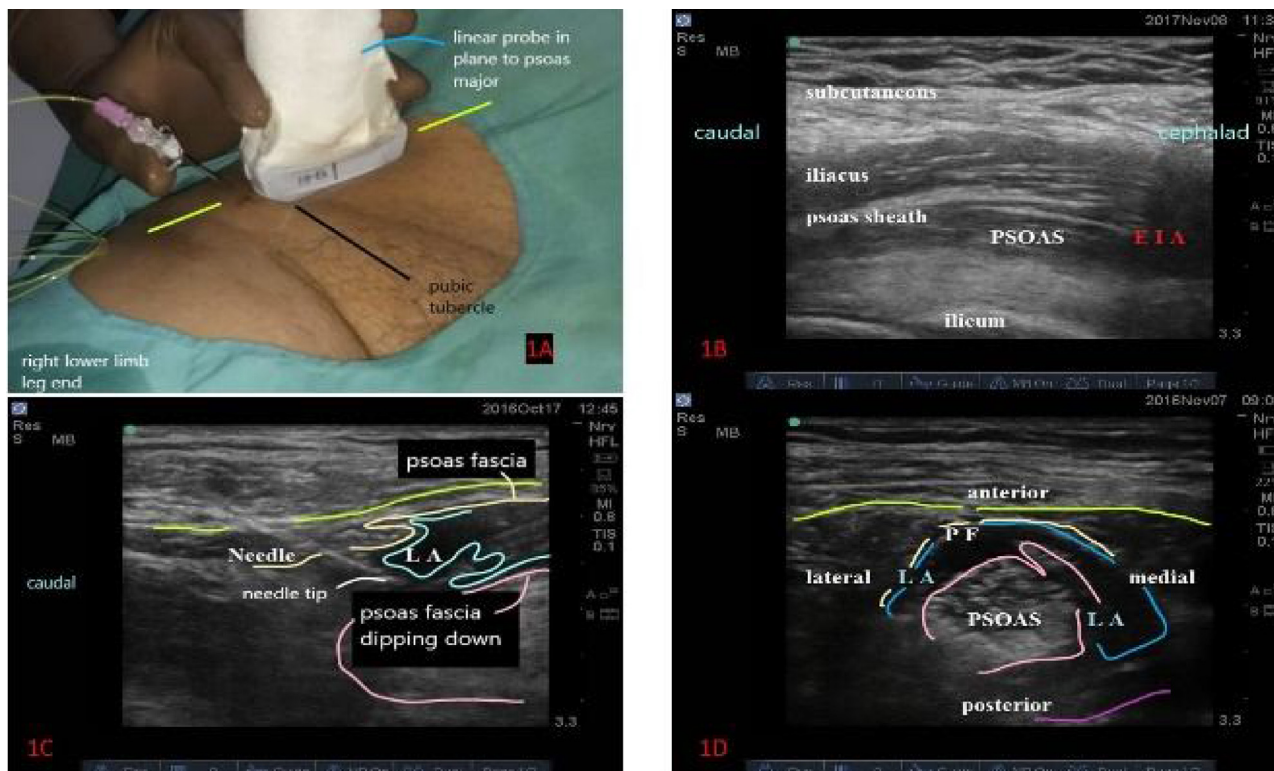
A, Placement of ultrasound probe immediately above the inguinal ligament with needle and catheter introduced in-plane; B, Longitudinal ultrasound image depicting the sonoanatomy for CPB, from below upwards are the Pma with the psoas sheath and the iliacus; C, Longitudinal ultrasound image depicting the needle insertion beneath the APf (anterior psoas fascia) in light yellow. LA injection (light blue) lifts the APf and depresses the Pma (light pink); D, Axial view depicting the spread of LA (light blue) around the Pma (light pink) lifting the APf (light yellow).
